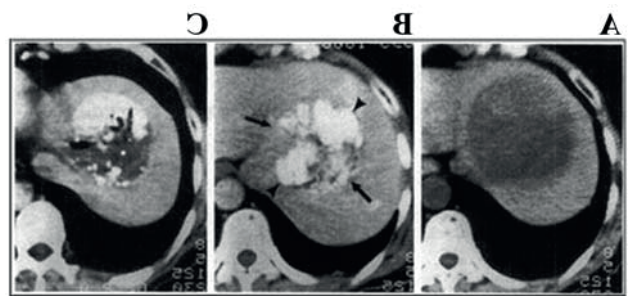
Multi-slice CT scans of a patient with liver tumor. A: Before treatment, the patient had a large liver tumor measuring 12x10 cm² in plane. B: At three months after treatment, the tumor size decreased to 7x8 cm² in plane and had a very high lipiodol marking (arrows). C: At six months after treatment, the tumor size had decreased further to 4x7 cm² in plane with lower lipiodol marking, showing liver regeneration.
